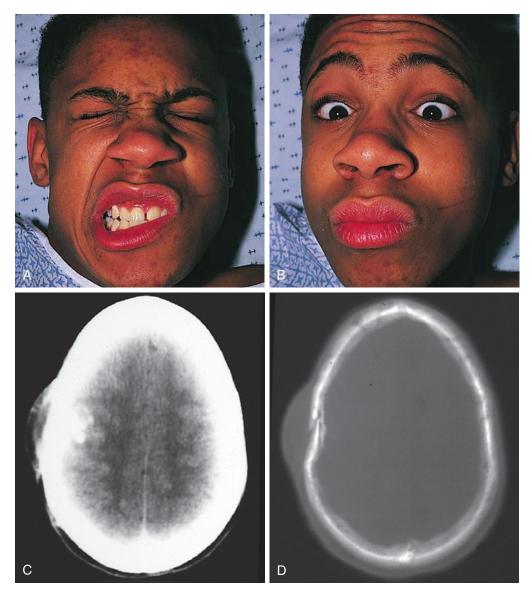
Central facial weakness. A and B, Weakness of the left face with relative sparing of the upper portion secondary to a lesion of the right cerebral hemisphere. There is flattening of the nasolabial fold and inability to retract the corner of the mouth, but the ability to close the eye and wrinkle the forehead is preserved. C and D, CT scans show the depressed fracture of the temporal bone that was responsible for this central facial palsy.
